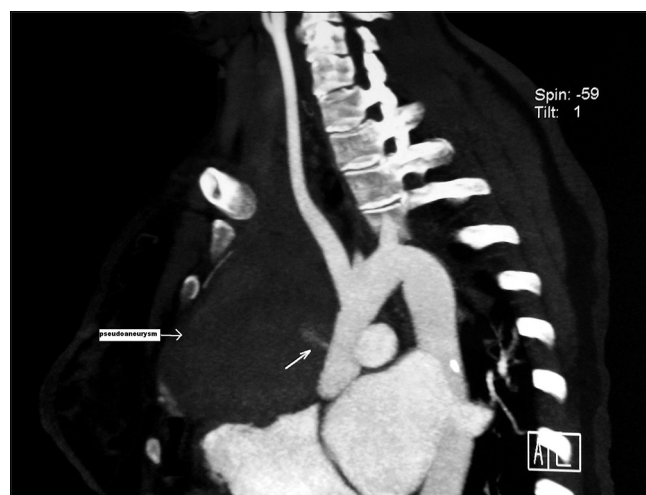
CT scan showing the pseudoaneurysm
